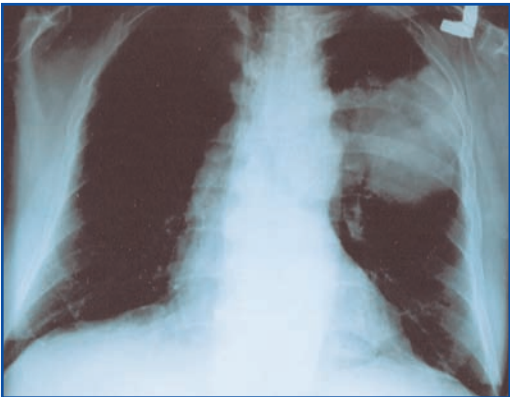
Antero-posterior chest X-ray, showing upper part of right lung.
